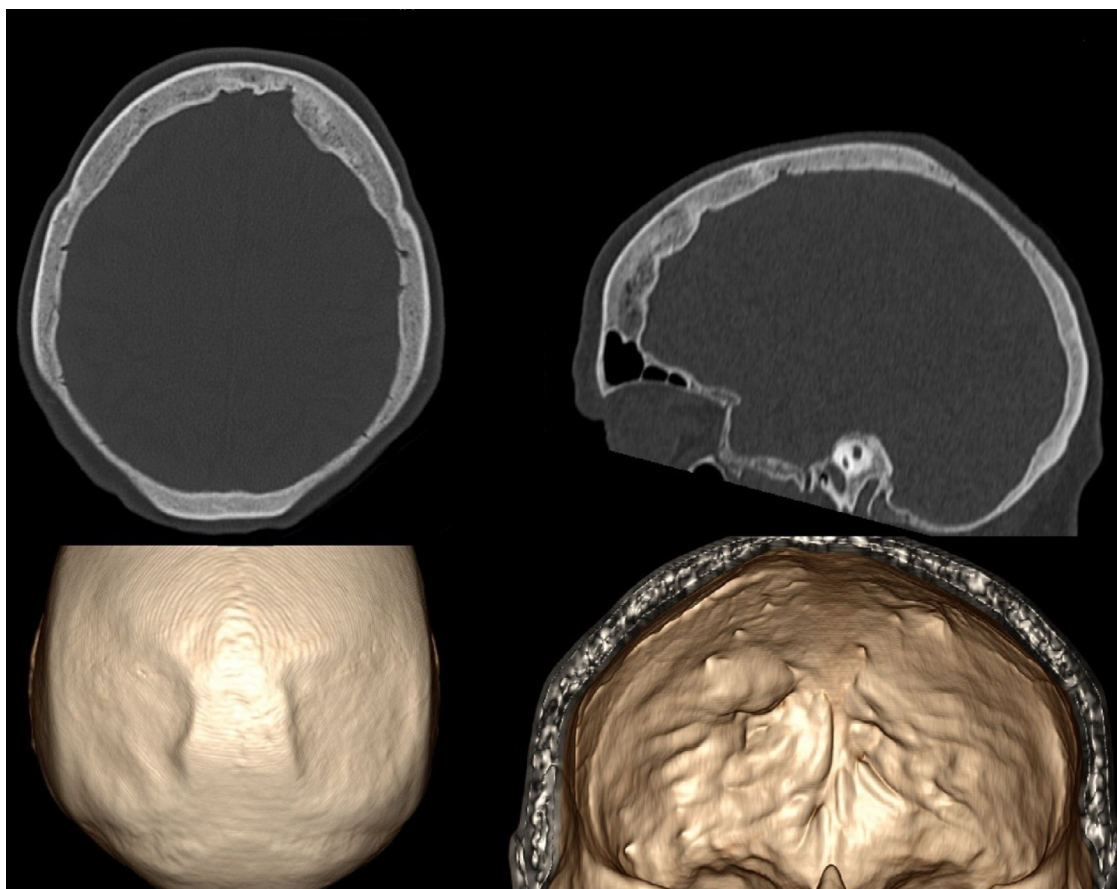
Computed tomography of the head in an 87-year-old woman undergoing imaging in the work-up of dementia. Hyperostosis frontalis interna (on the right) as well as marked bilateral thinning of the parietal bone can be seen (on the left). The volume rendered reconstructions show the aspect usually seen on gross morphology.
